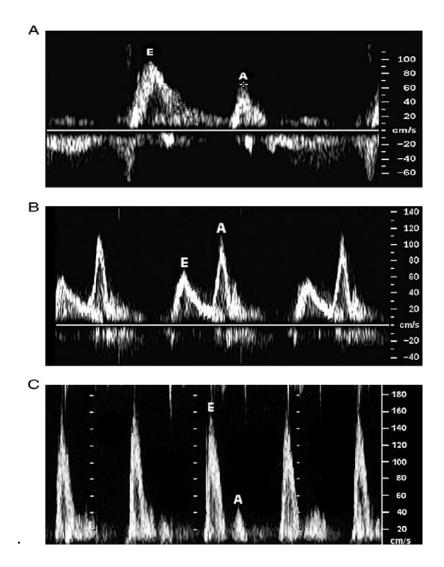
shows transmitral Doppler flow pattern
